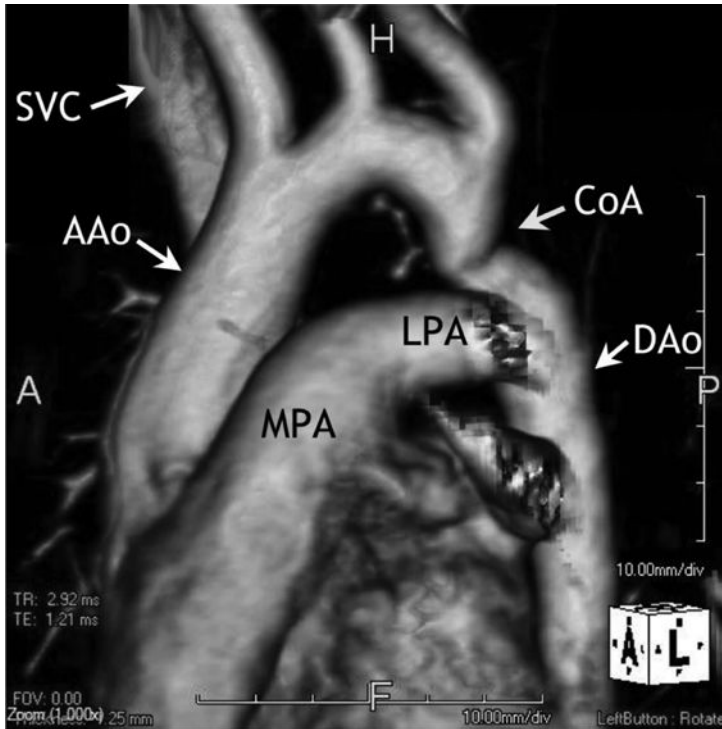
Three-dimensional reconstruction from an MRI scan in a teenager with coarctation of the aorta. MPA, main pulmonary artery; LPA, left pulmonary artery; AAo, ascending aorta; SVC, superior vena cava; CoA, coarctation; DAo, descending aorta.
